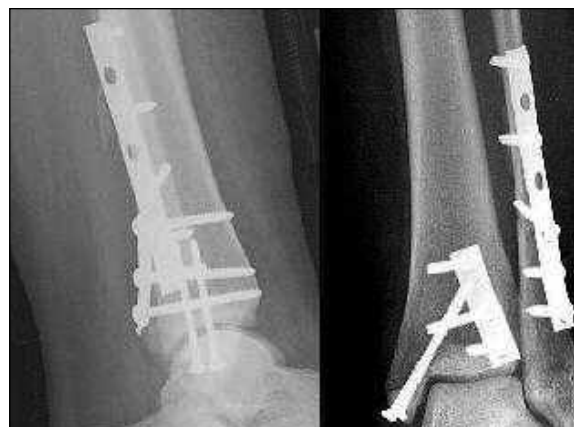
Postoperative anteroposterior and lateral radiographs. An antiglide plate has been applied to the fibula. Lag screws and a buttress plate have been used to fix the posterior malleolus.
